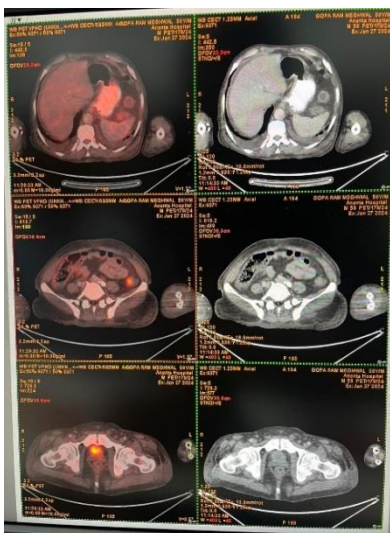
Slides of PET-CT
